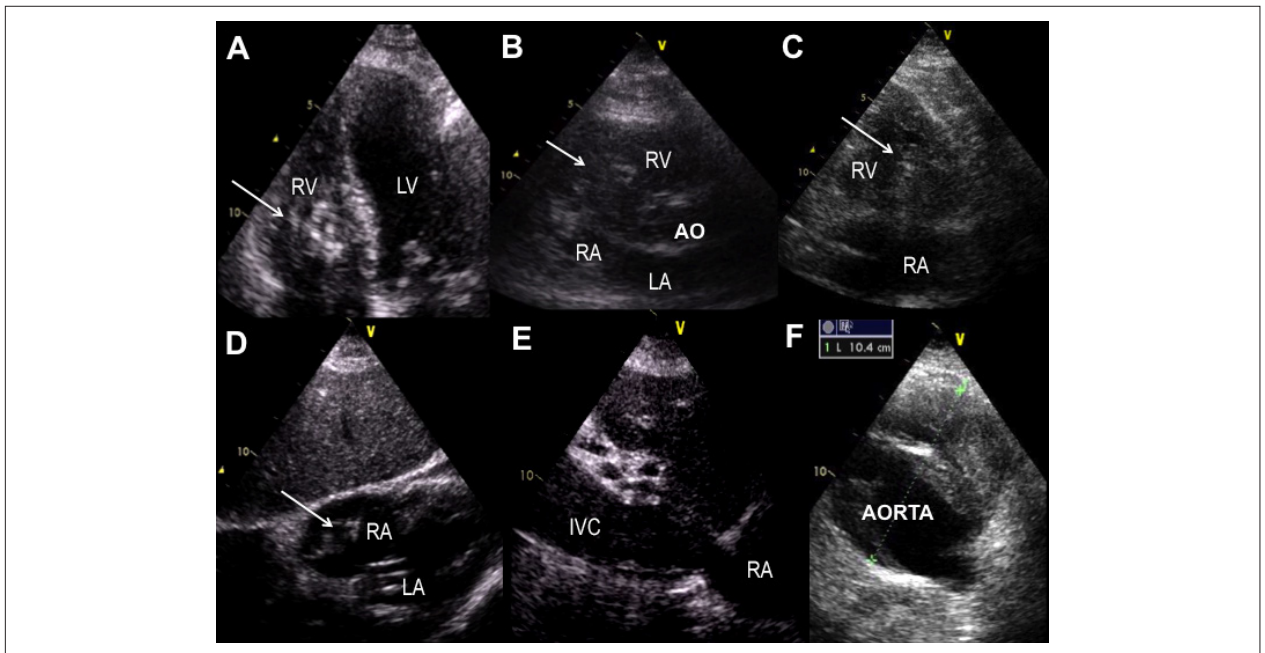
Images from transthoracic echocardiography. Large dimension thrombus (arrows) in right cardiac chambers depicted on apical four-chamber view (A), parasternal short-axis view of the basal right ventricle (B), parasternal long-axis view of the right ventricle inflow (C) and subcostal view (D). Extensive thrombosis of the inferior vena cava (E) and an aortic aneurysm with superimposed thrombosis (F) on subcostal view. Ao: Aorta; IVC: Inferior vena cava; LA: Left atrium; LV: Left ventricle; RA: Right atrium; RV: Right ventricle.
